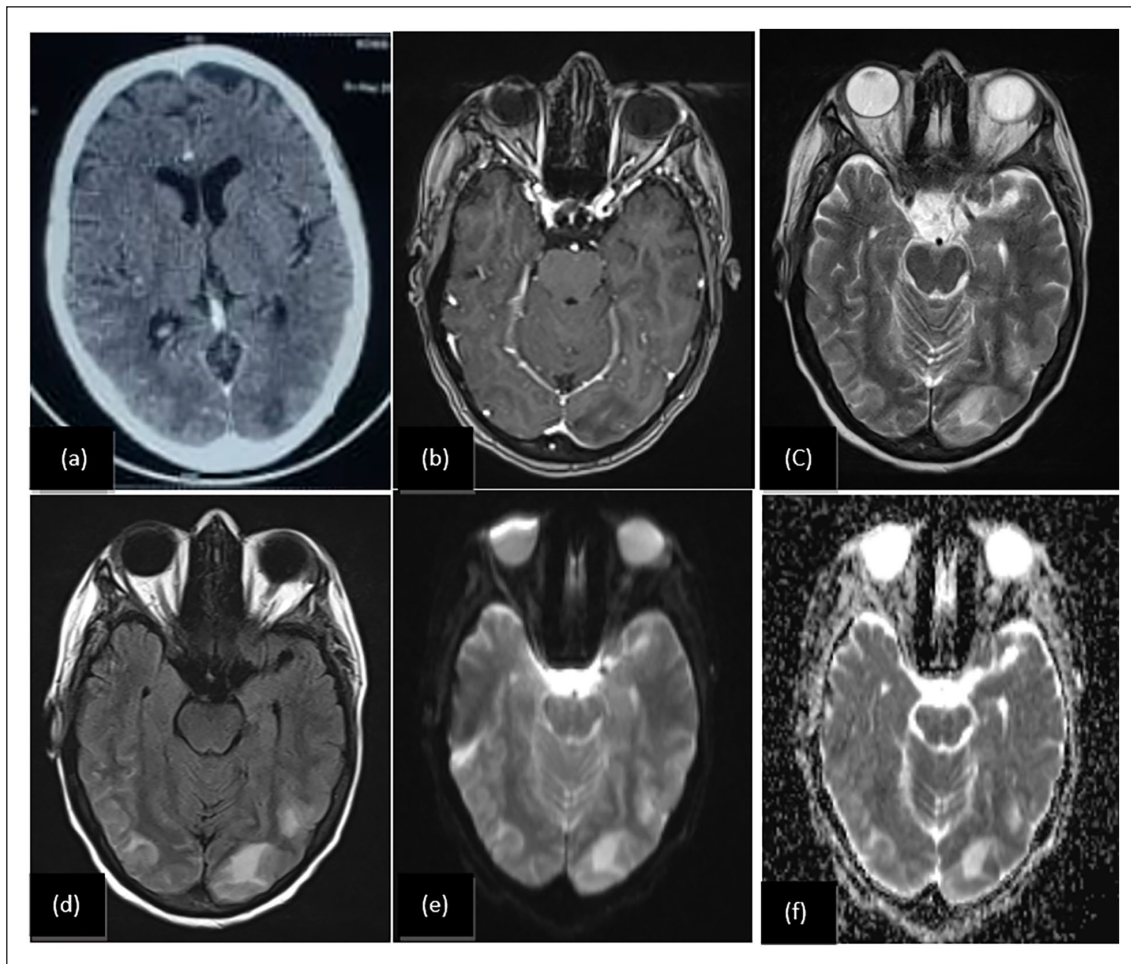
Brain axial CT with occipital hypodensity (a) and brain magnetic resonance imaging with post-contrast T1 (b) T2 (c) T2 fluid-attenuated inversion recovery (FLAIR) (d) apparent diffusion coefficient (ADC) (f) and diffusion (e) axial sequences: We noted bilateral juxta and subcortical parieto-occipital, with cortical involvement, T2 and FLAIR high signal ((c) and (d)), diffusion and ADC high signal ((e) and (f)), and low signal occipital area with discrete gyral enhancement post-contrast T1 (c), suggesting a posterior reversible leukoencephalopathy.
